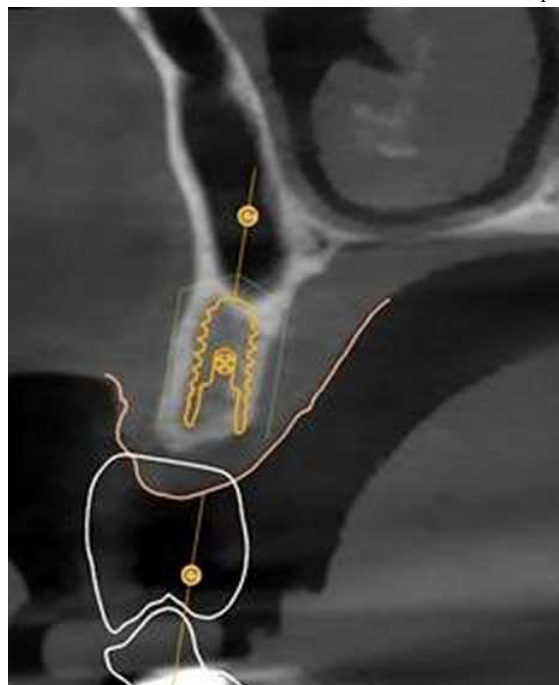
Figure Cross section of maxilla in 15 region showing surgical guide planning after merging CBCT data with stereolithography data for guided implant placement (annotations: prosthetically driven implant positioning; soft tissue data merged with CBCT; virtual prosthesis planned).
